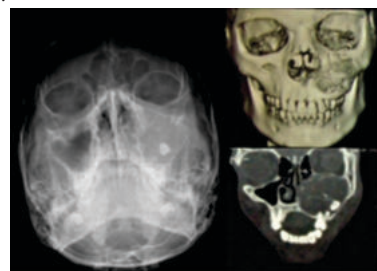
Radiographic investigations of the lesion
